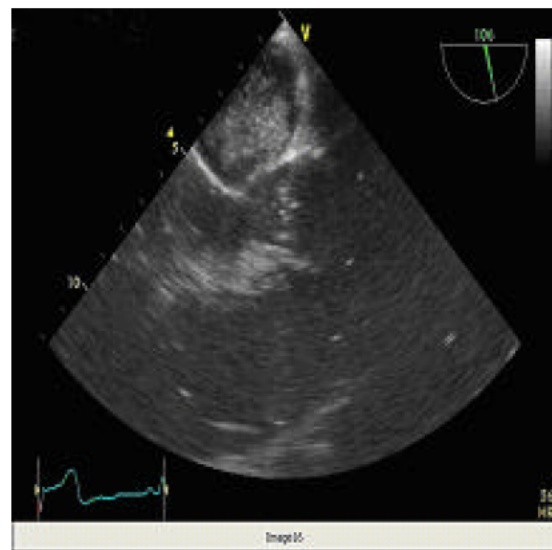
Transesophageal view on 110° showed large LA myxoma
